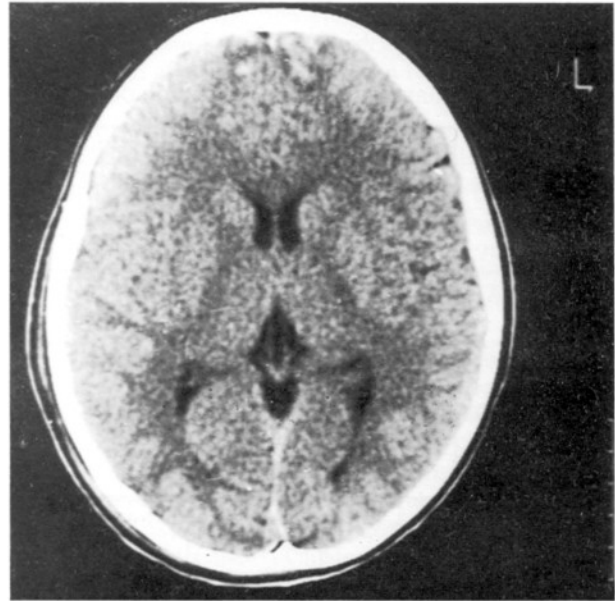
CT-scan six hours after admission showing resolution of subdural hematoma with normal sized ventricles. Note that the frontal contusion is more remarkable.
